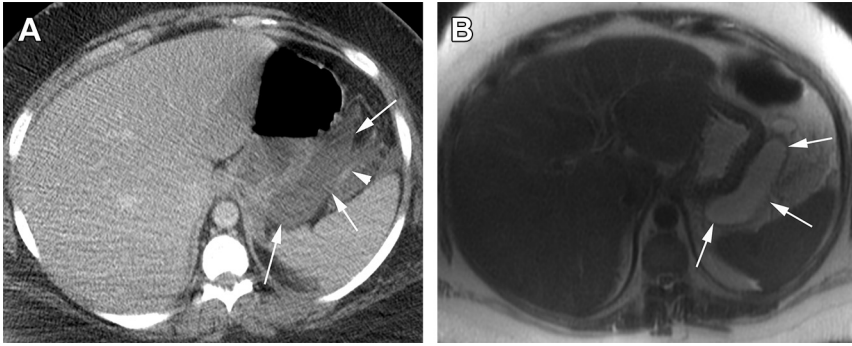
Early pseudocyst formation in a patient with interstitial edematous pancreatitis. The 35-year-old woman with heavy EtOH abuse had transient organ failure and was not feeling well clinically. (A) The axial CT image demonstrates a fluid collection next to the stomach (*arrows*) that shows early partial rim enhancement indicative of early formation of a wall. The presence of nonliquefied material cannot be excluded. The arrowhead indicates the tip of the pancreatic tail. (B) Same patient as Fig. 11A. MR was obtained to assess if she had developed extrapancreatic necrosis. The axial T2-weighted single-shot fast spin echo MR image obtained a few days later depicts a homogeneous fluid collection of high signal intensity (*arrows*) with a thin early capsule but without evidence of nonliquefied material.
